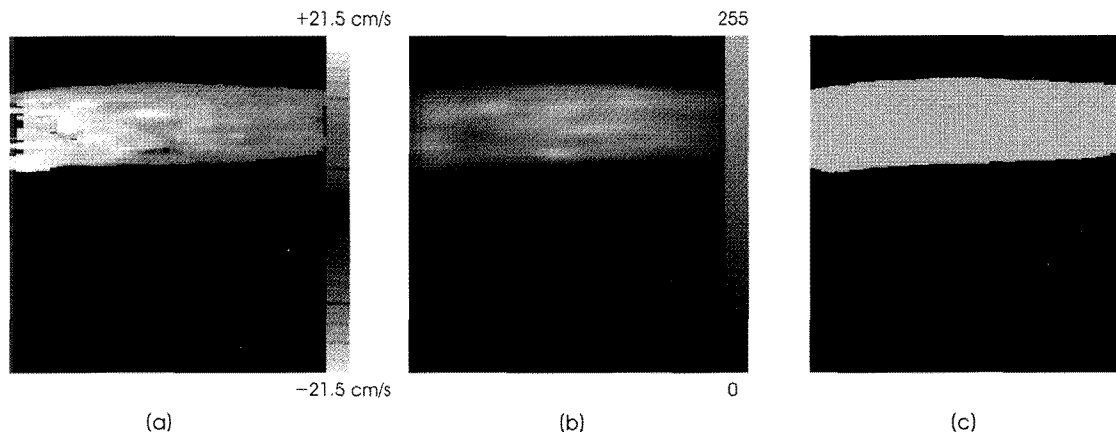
Pre-scan-converted color Doppler image with (a) velocity estimates and (b) power estimates, and (c) flow mask.
